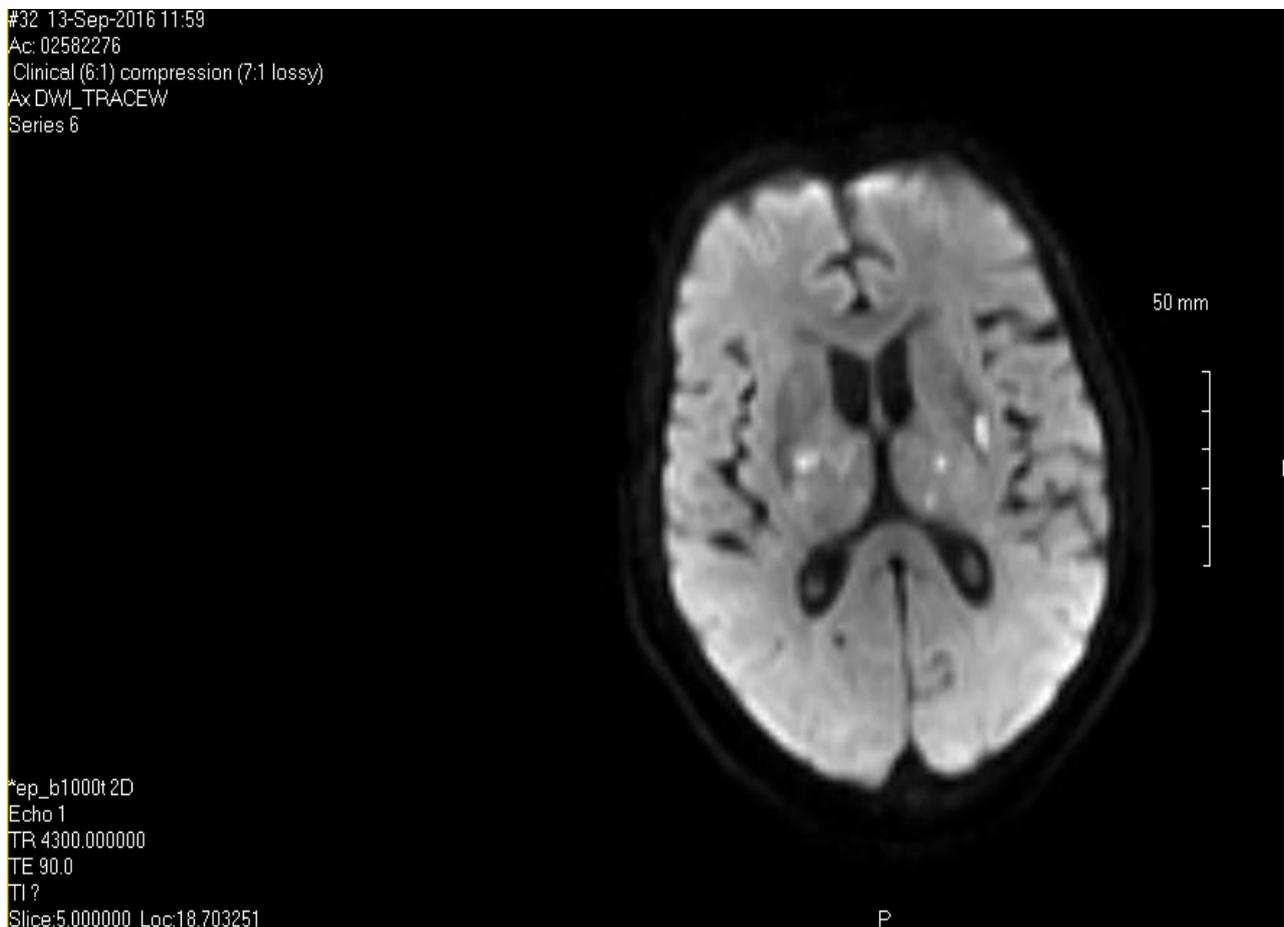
Axial view of MRI brain showing multiple small embolic infarcts (DWI)
